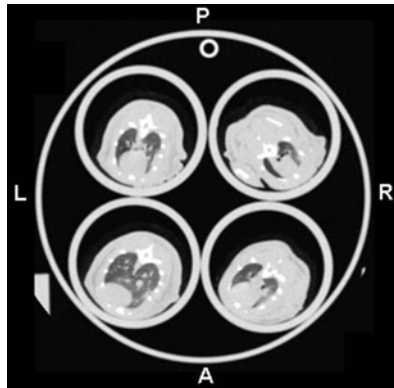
A transverse CT image showing four subjects within the sedation enclosure.
